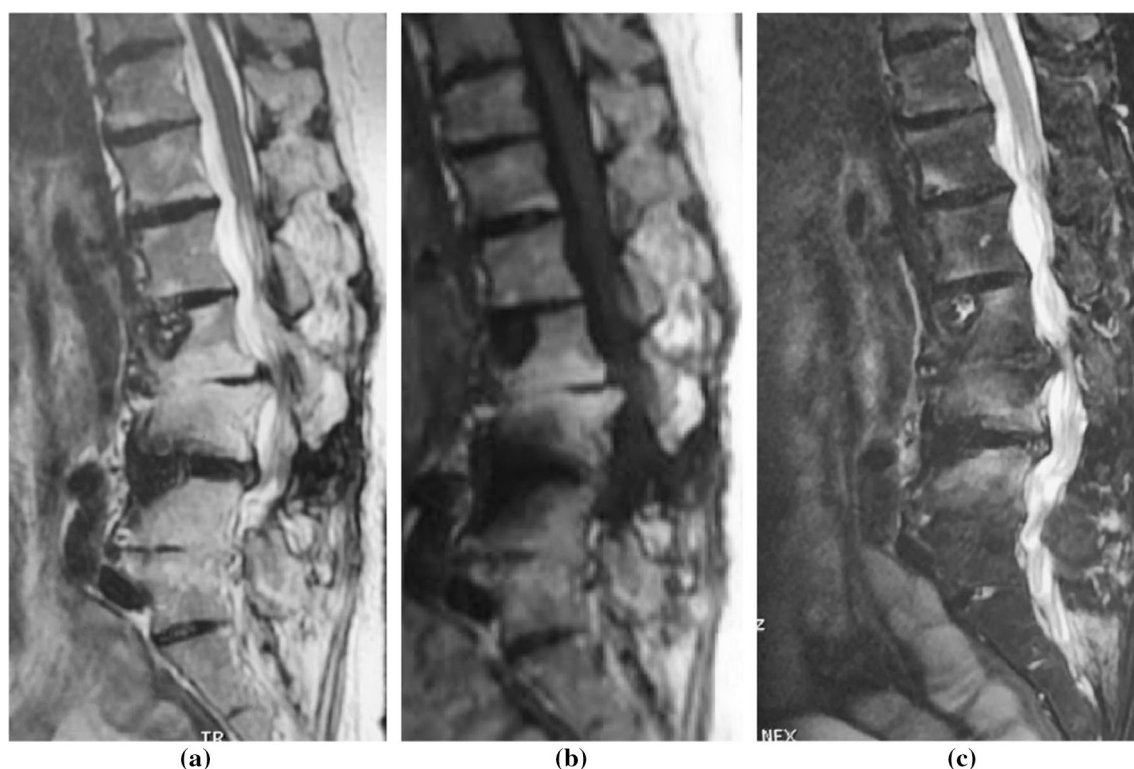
MRI showing multiple level central intradiscal low signal on T1 and T2 weighted sequences consistent with disc calcification, and the L4L5 anterior defect in hypointensity signal on T1 and T2 (a, b) with bone marrow oedema of the adjacent bodies on FAT SAT (c)
